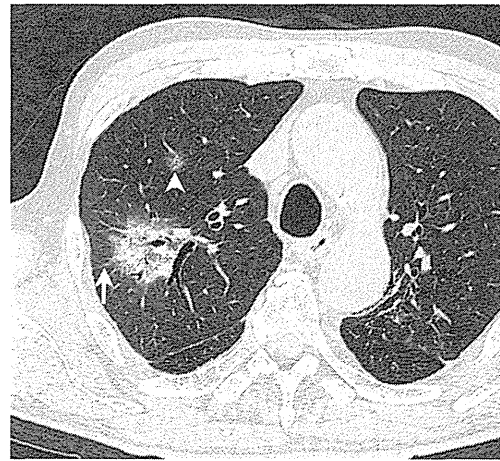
Acute transformation (acute type) in a 67-year-old male patient with smouldering type ATLL, 21 days after the onset of fever. Transverse CT image (1-mm thickness) at the level of the aortic arch shows mass-like consolidation with surrounding GGO and air bronchogram and interlobular septal thickening (arrow). Small nodule is present in the right upper lobe (arrowhead)
